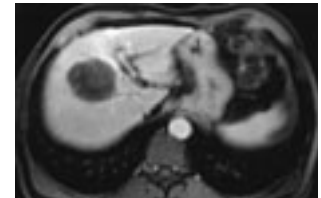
Contrast enhanced MRI after treatment with DEB TACE revealing complete tumor necrosis
